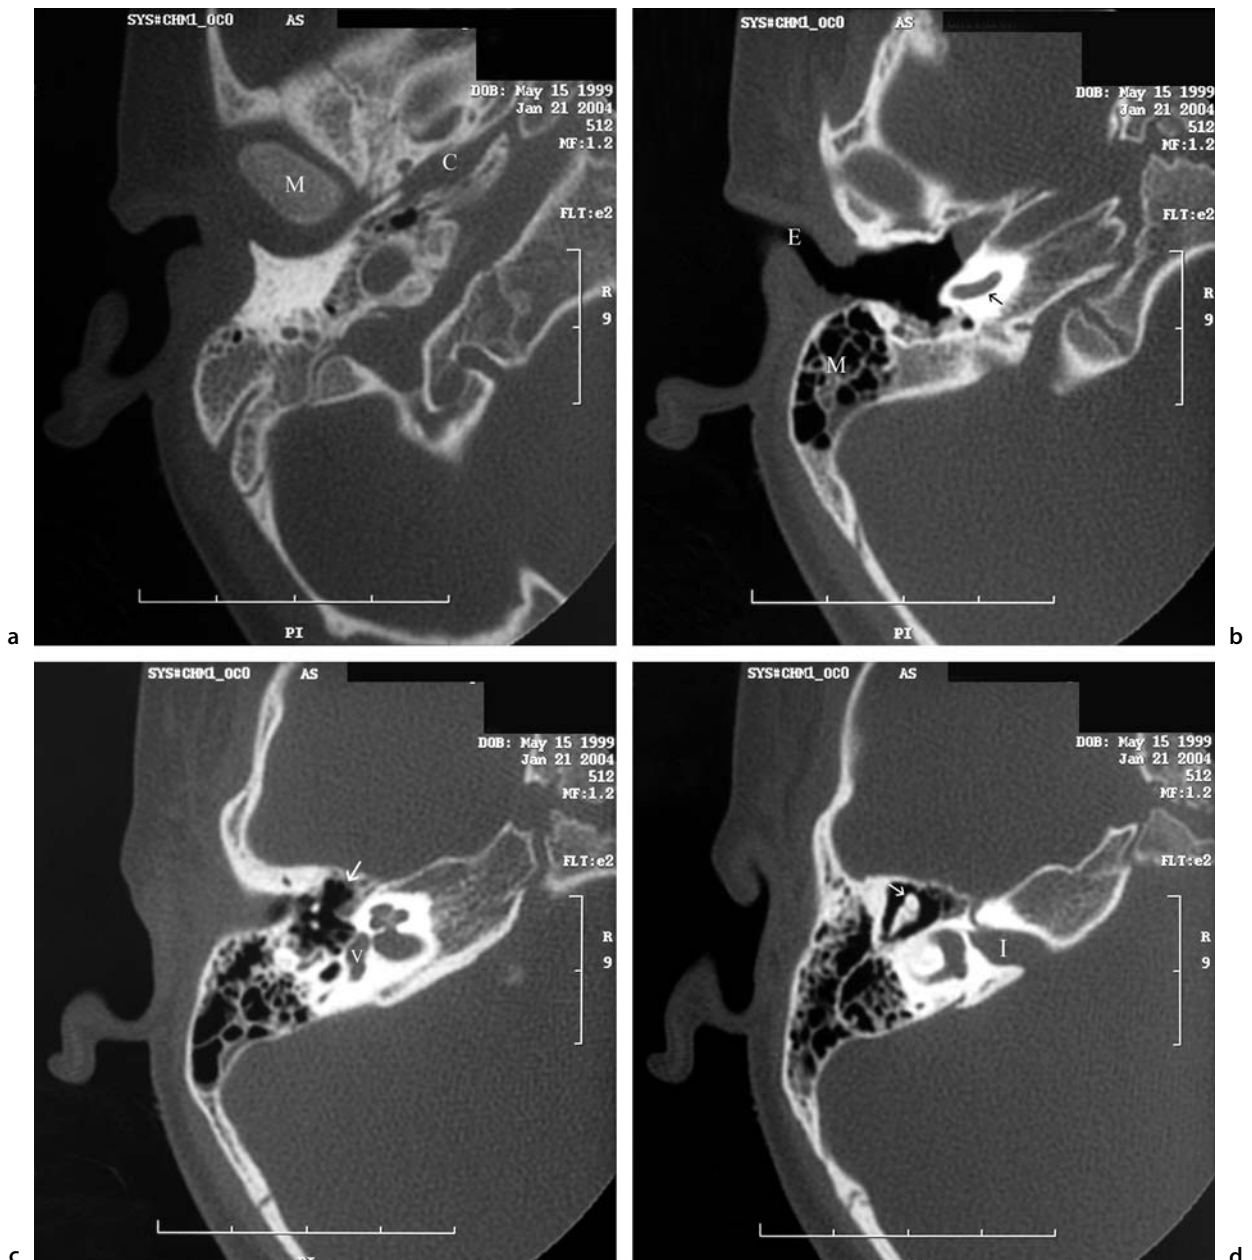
CT of the temporal bones of a normal right ear and normal paranasal sinuses
